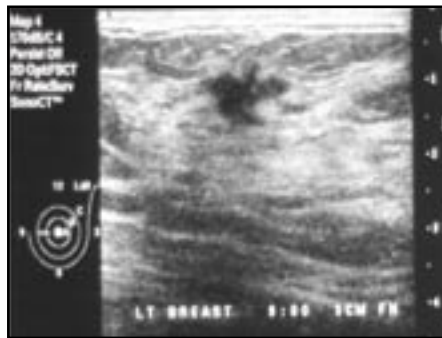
Solid lesion with stellate borders – this is a malignant sonographic appearance (note: this lesion is extremely hypoechoic; it is less echoic ['less white'] than the surrounding normal parenchyma)
